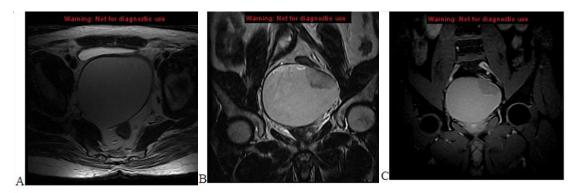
(A & B) Ax and coronal T2w MRI shows large cystic lesion posterior to the urinary bladder with soft tissue nodule at its left superior aspect, (C) coronal Gd-enhanced spoiled gradient (SPGR) T1w shows intermediate SI of the fluid content with no enhancement at the soft tissue nodule.
